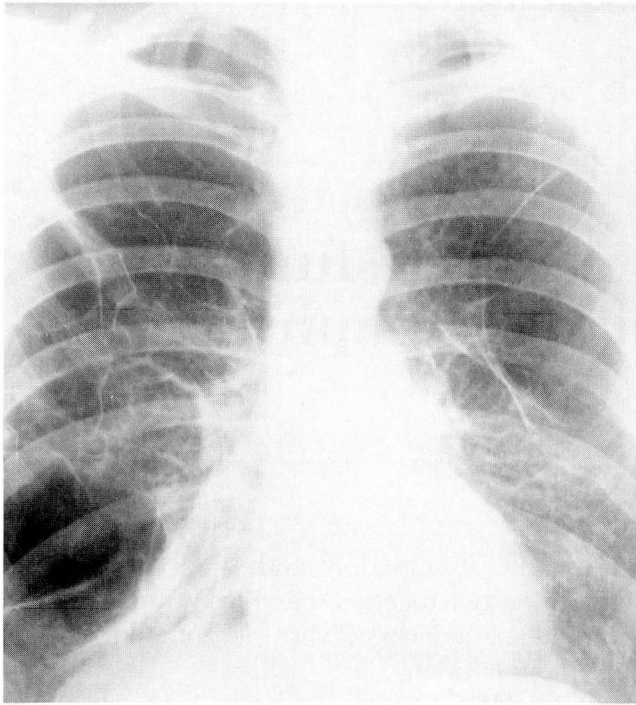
Posteroanterior chest radiograph at age 25 showing severe bilateral upper lobe bullae.
